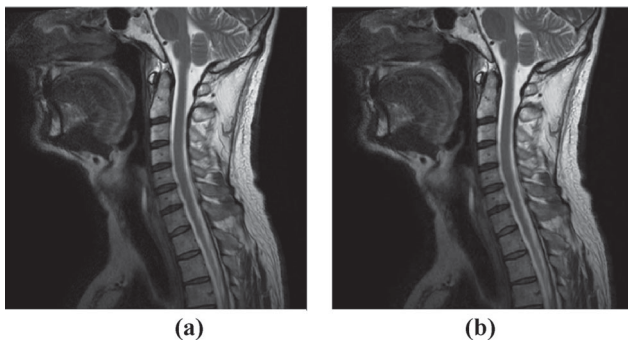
MRI Cord image from data set-2 of Table 1 (a) Original Image (b) Image reconstructed with VLIC method [35].
